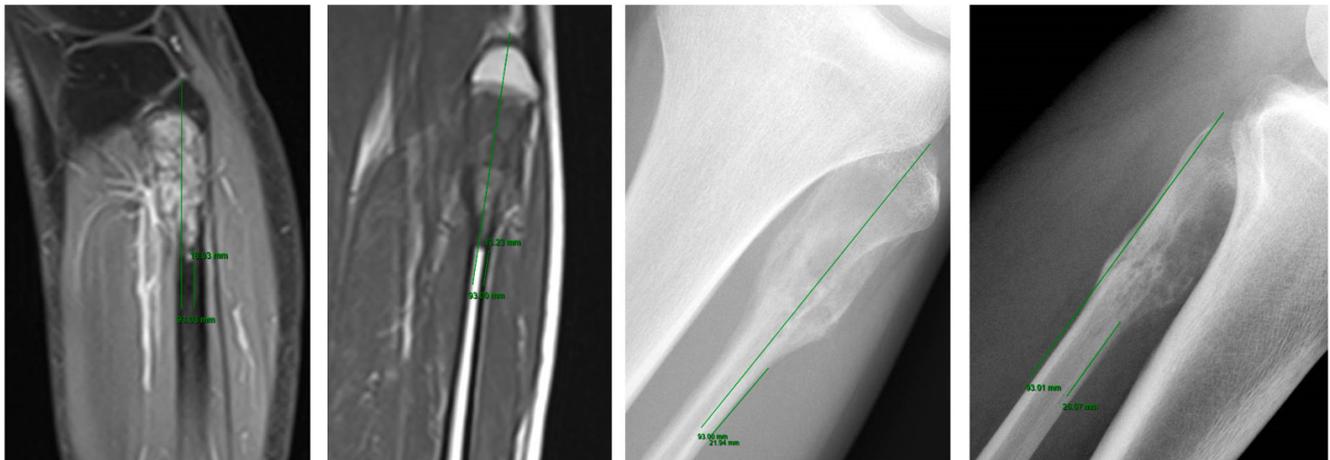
This figure demonstrates the margin measurements on a fibula with osteosarcoma from a sagittal T1 fat-suppressed MRI, coronal T1 MRI, A-P plain film X-ray, and a lateral plain film X-ray respectively from left to right. The bony resection was 9.3 cm as indicated by the long green line in each image, and the pathology reported a margin of 1.6 cm. The margins measured from each image in the figure and the respective differences from the pathology value is tabulated in Table 1.
